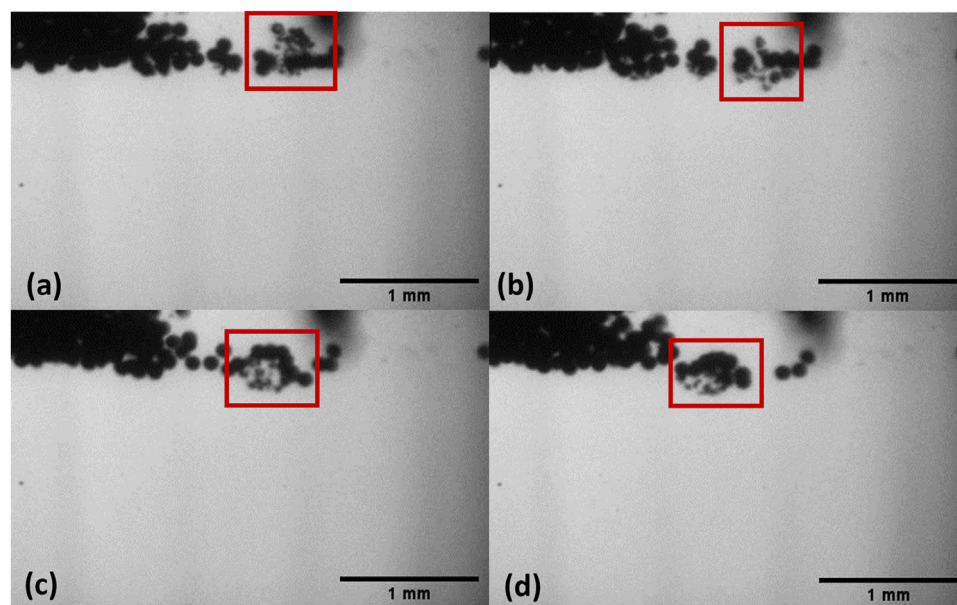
(a–d) Formation and movement of a Sonovue microbubble cloud (Video S3), driven at 0.5 MHz, 2.8 MPa peak negative focal pressure, 5% duty cycle and 3.3 Hz pulse repetition frequency. Microspheres (106 µm diameter) can be seen moving towards the cloud (red outlined section) and travelling with it before rebounding off the cavity edge. Images were captured at 4 × magnification, at 100,000 fps. The direction of ultrasound propagation is from the top to the bottom of each image.
